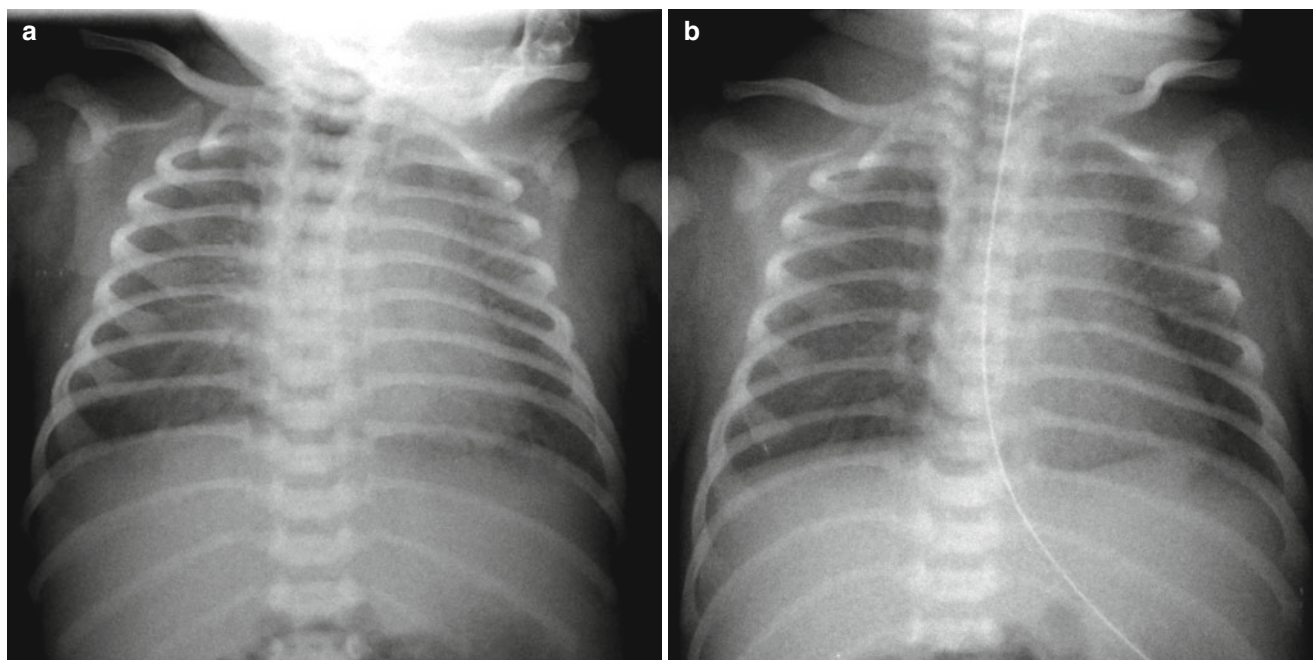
TTN in a 40-week-gestational-age newborn. (a) Bilateral diffuse faint haziness and mild cardiomegaly are noted on a frontal radiograph obtained on the day of birth; tachypnea without cyanosis
